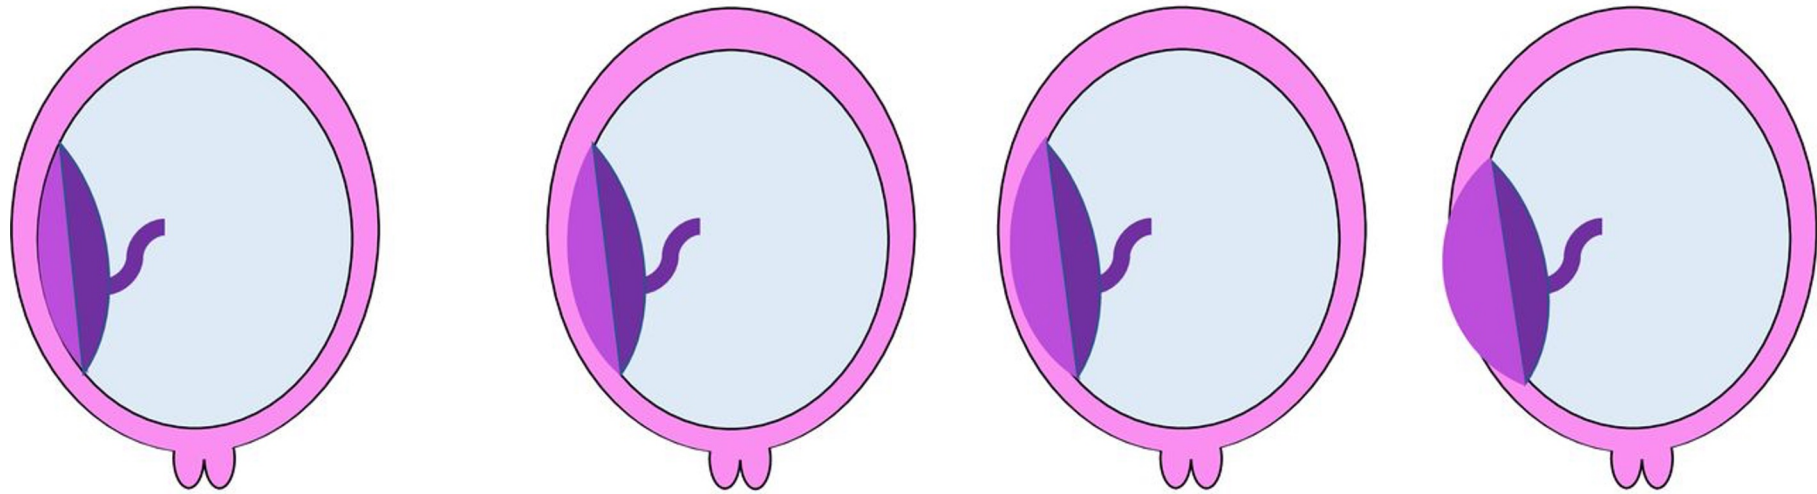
Figure from Otto Textbook of Clinical Echocardiography
